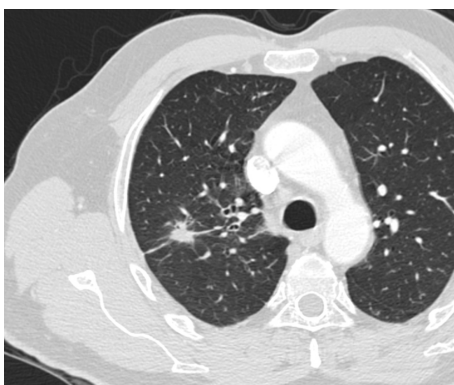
Typical appearance of a malignant solid pulmonary nodule at high-resolution computed tomography (Philips 16-slice computed tomography, slice thickness 1.25 mm) in a 59-year-old male patient. The lesion was located in the right upper lobe, had a maximum diameter of 24 mm and proved to be an adenocarcinoma at surgery.
